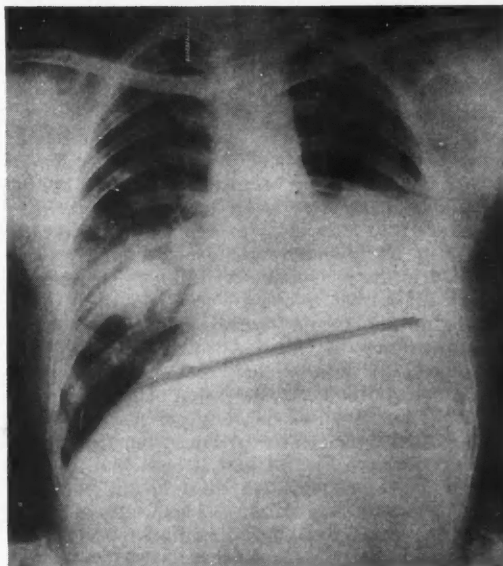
X-ray film of chest taken after excision of the right middle lobe. Note increase in extent of tumor mass in the left lung.
